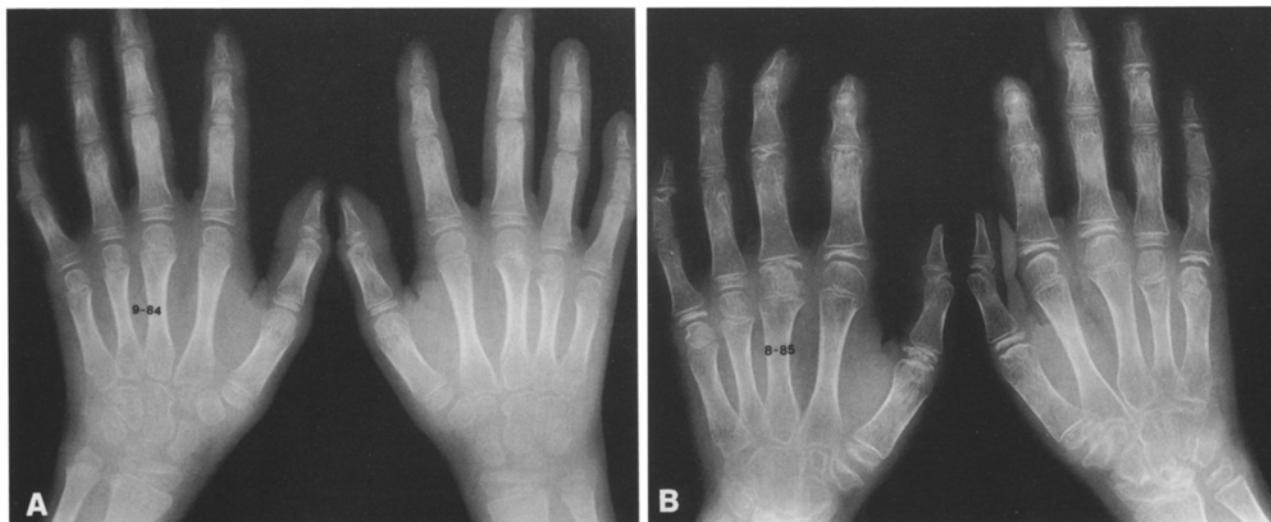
A Frontal radiograph of the hands at the time of appearance of the skin nodules. Besides the soft tissue nodules no radiographic abnormality was noted. The carpal size is normal. B Radiograph of the hands obtained one year later. Observe the marked destructive changes involving the carpus, metacarpophalangeal joints and proximal and distal interphalangeal joints
